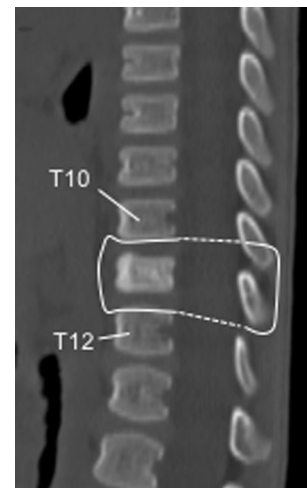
Preoperative sagittal CT reconstruction revealing the invasion of T11 by the sarcoma
